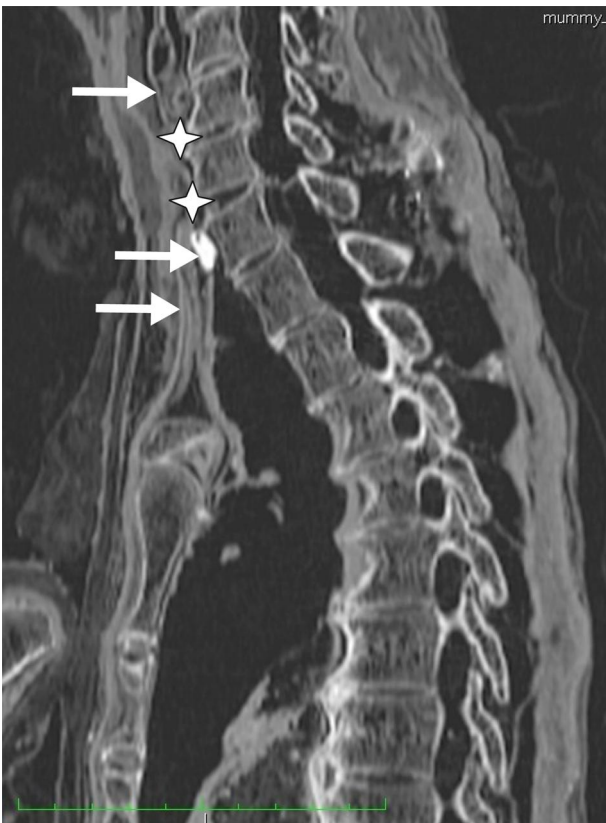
Sagittal CT section image of the neck of Ramesses III. Arrow=foreign object. Stars=wound margins; embalming material has seeped into wound and bone. Triangles=skin above and below the wound.
